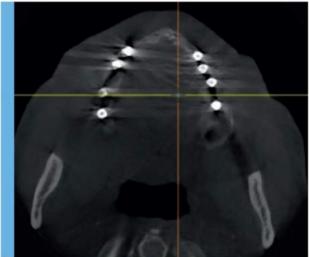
CT image on the alveolar crest in the period following the implantation.
